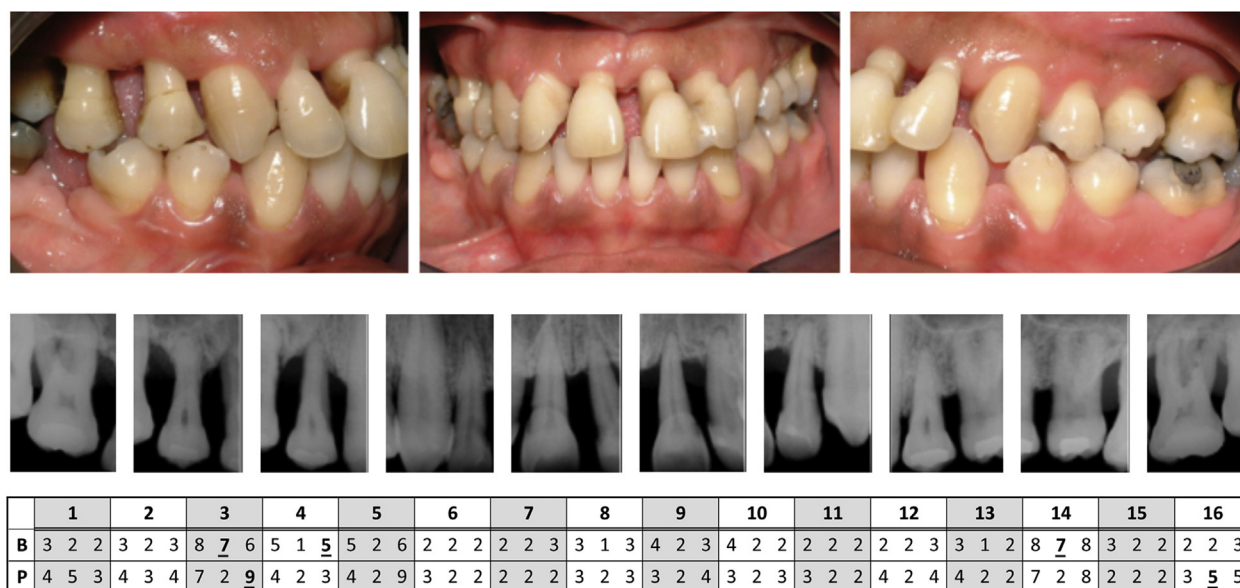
Clinical photographs, radiographs, and probing depth measurements at 1 year postperiodontal therapy. A bold and underlined number denotes bleeding on probing. B: Buccal. P: Palatal.
